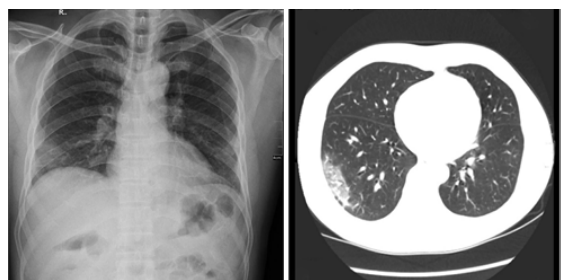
Radiological findings of the third patient. (a). CXR, bilateral pericardial pneumonic infiltrate; (b). Chest CT (transverse), subpleural ground glass opacity with interlobular septal thickening.
